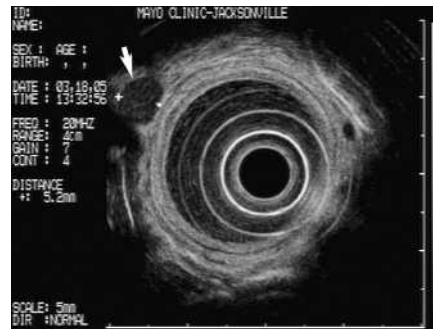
The endoscopic ultrasound image shows a round, hypoechoic lymph node with sharp margins, 5.2 mm in size (arrow).
